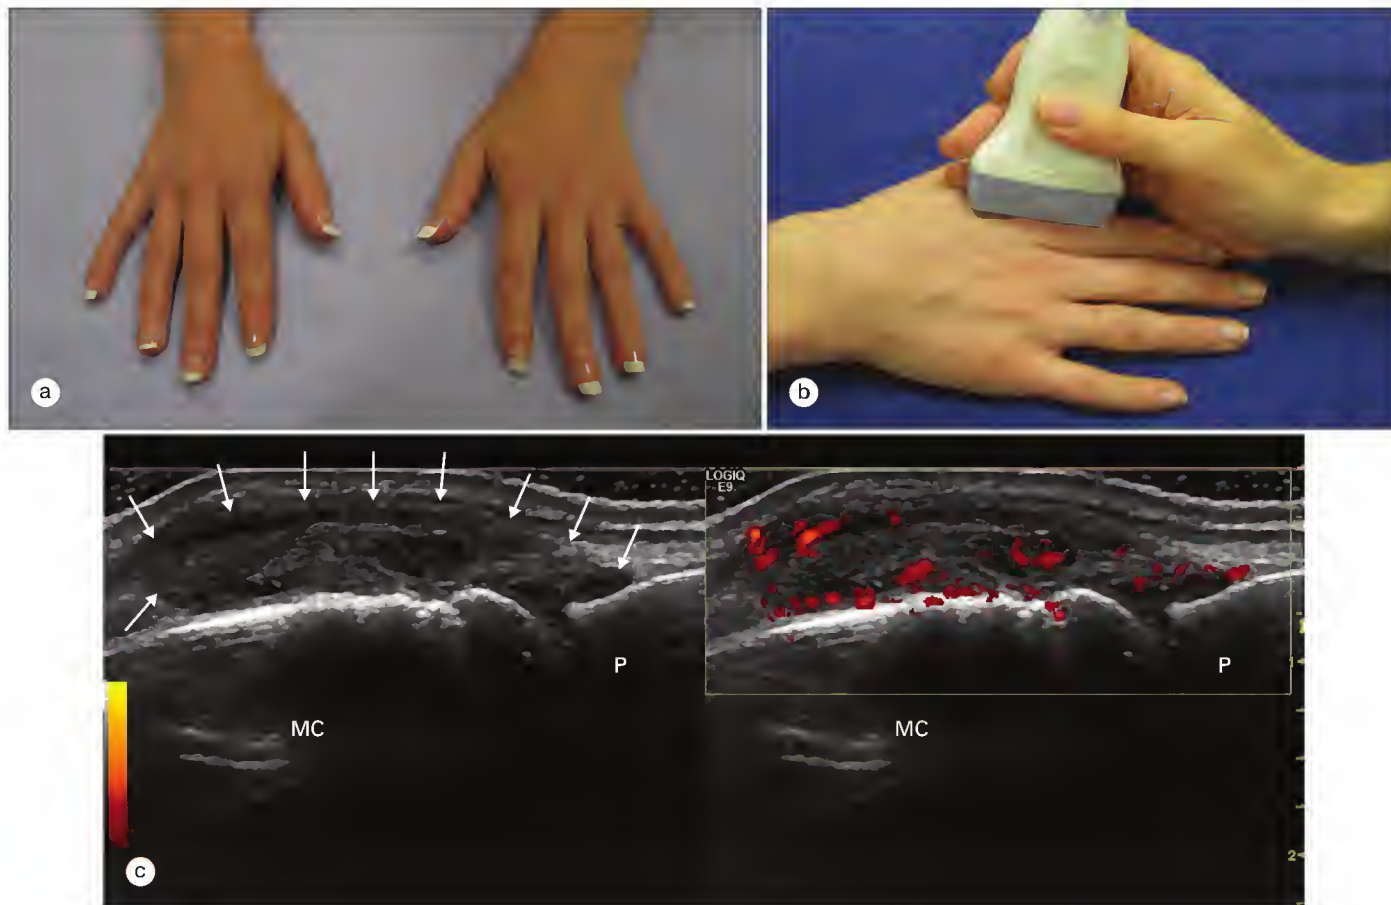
(a) Patient with puffy fingers and arthralgia. (b) Technique of performing an ultrasound examination on a metacarpophalangeal joint. The dorsal longitudinal plane is shown. (c) Marked gray-scale synovitis is demonstrated (arrows) in longitudinal view. There are also marked Doppler signals within the synovium. MC, metacarpal head; P, phalanx.
